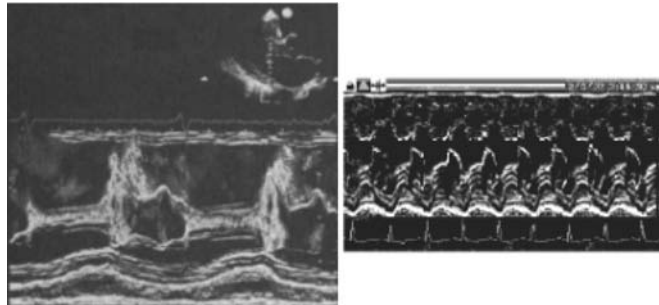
Example of a B-mode sonogram (source Internet)
